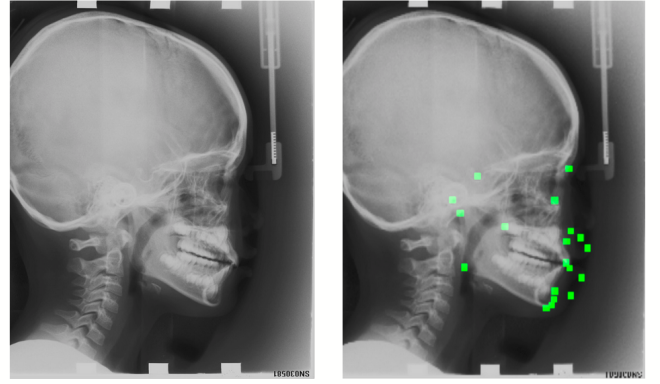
Overview of the Cephalometric X-Rays dataset.
